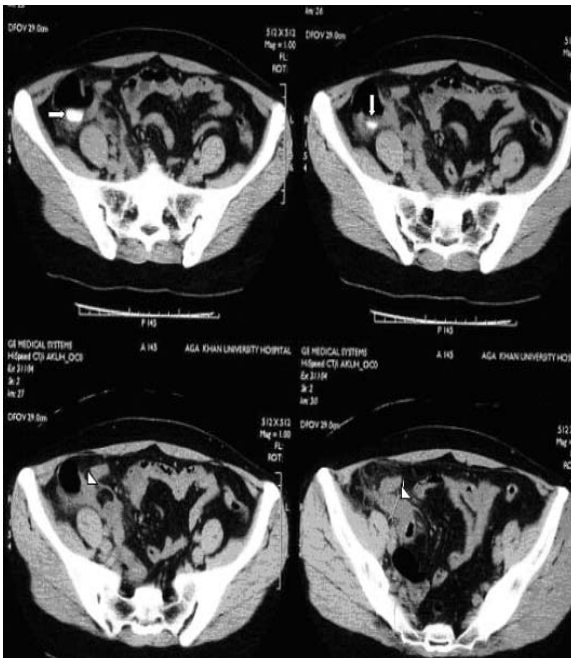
Computed tomographic sections showing appendicolith (arrows) in the top two sections, and demonstrating enlarged appendix in the bottom two images (arrowheads).
